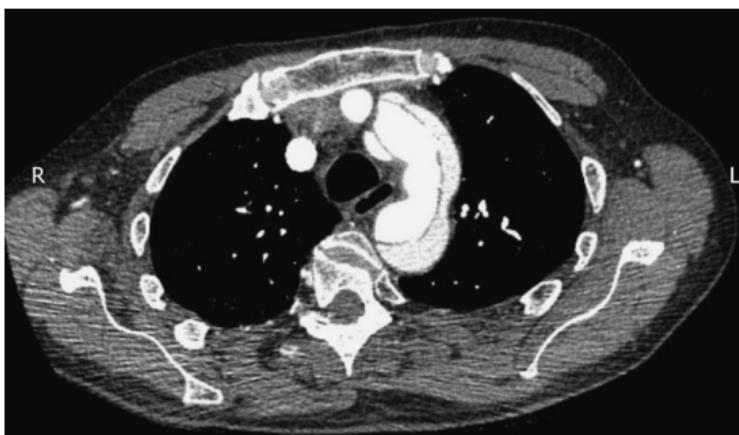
CT scan showing dissection of the aortic arch.
